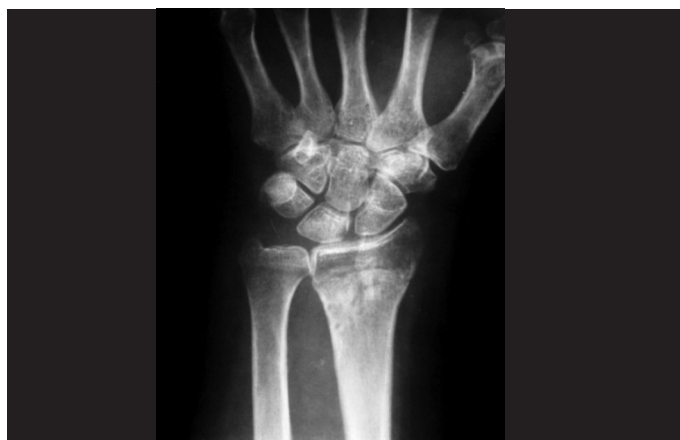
Radiograph on wrist in posteroanterior view after removal of the Kirschner wires, showing the final result from treatment of the fracture of the distal radius.
